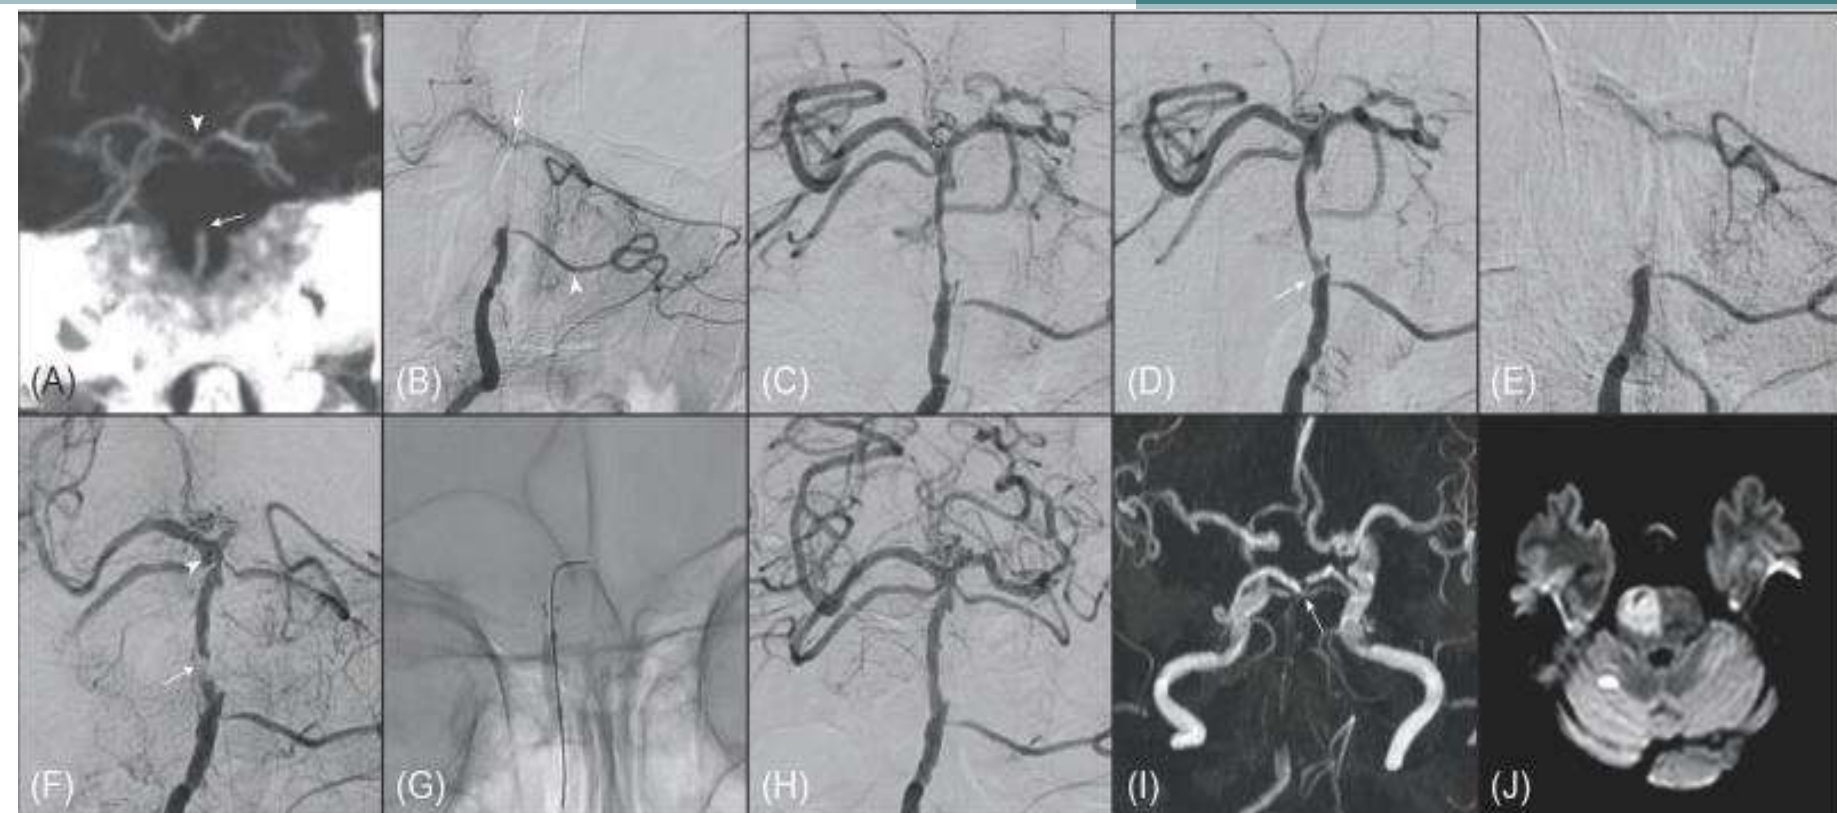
A representative example of 80-year old female patient with truncal-type occlusion. (A) On preprocedural computed tomography angiography (coronal view of maximal intensity projection image), occlusion of basilar artery (BA) was noted (arrow). On the computed tomography angiography, BA bifurcation was clearly seen (arrowhead). (B) On digital subtraction angiography (anteroposterior view), BA occlusion was also noted. BA bifurcation (arrow) and bilateral posterior cerebral arteries were seen by collateral flows through left anterior inferior cerebellar artery (arrowhead). (C) BA bifurcation and bilateral posterior cerebral arteries were definitely verified by stent-through flow. (D) By 1 stent retriever thrombectomy, BA occlusion was recanalized, however, focal stenosis with angiographical haziness was noted.
